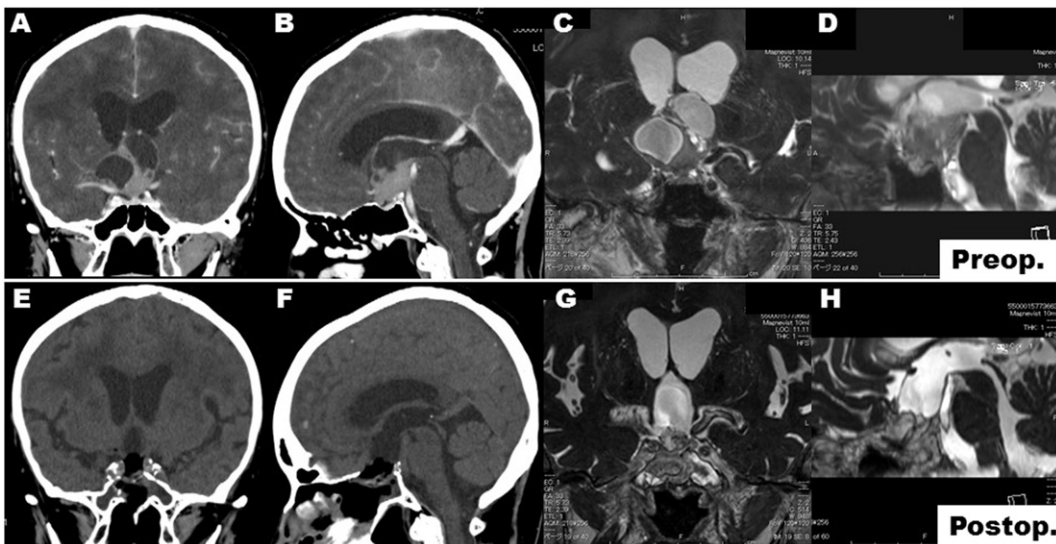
MRI shows a large multicystic suprasellar tumor extending into the third ventricle and caused non-communicating hydrocephalus (A, C). Calcified components are not detected on preoperative computed tomography (A, B). The tumor is gross-totally resected through an extended eTSS (A–D). Non-communicating hydrocephalus (A, C) is in remission (E, G).
